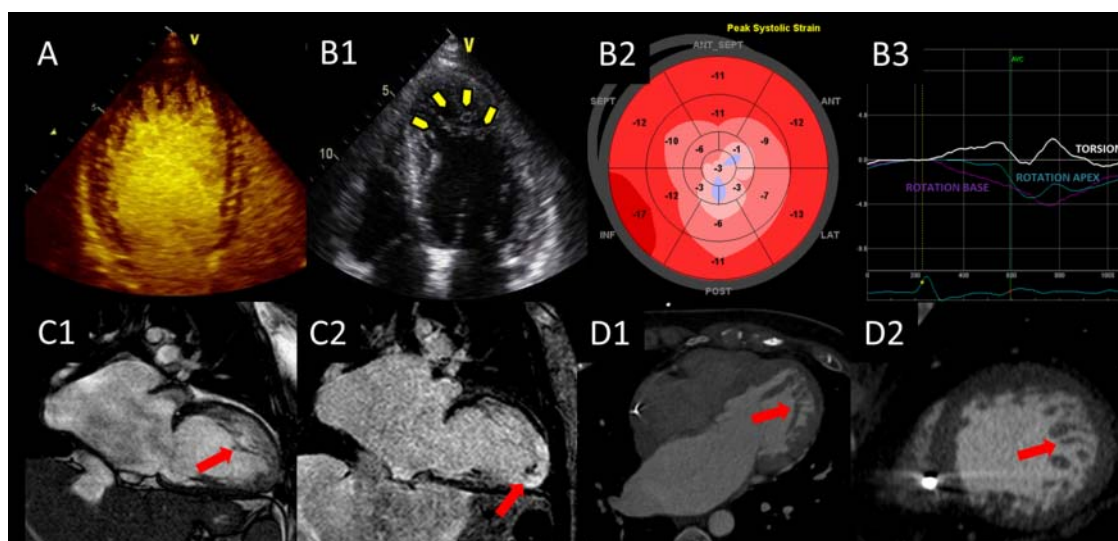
Methods to improve the diagnosis of left ventricular non-compaction (LVNC). (A) Use of echo contrast agent can aid visualisation of deep recesses in the trabeculated myocardium. Patient with LVNC suggested on 2D echocardiography (B1), demonstrated reduction in longitudinal strain at the site of greatest trabeculation (apex) on a 2D speckle-tracking polar map (B2) and absent LV torsion as a result of unidirectional rotation of the base and apex (B3) (normally, basal rotation is clockwise while apical rotation is counter-clockwise). The apical versus base strain difference has been previously validated with tissue Doppler-based strain analysis.³³ We have demonstrated the same with speckle tracking-based strain in panel B2. Example of LV trabeculation seen on steady-state free precession cardiac MRI (cardiac MR (CMR)) (C1, red arrow) with an apical thrombus (C2, red arrow) and myocardial fibrosis/scar (C2, bright area, red arrow) noted on late gadolinium enhancement imaging (C2). (D1, 2) Clearly delineated LV trabeculation on cardiac CT images (red arrows), demonstrating its superior signal-to-noise ratio and contrast-to-noise ratio in comparison with echocardiography and CMR.
